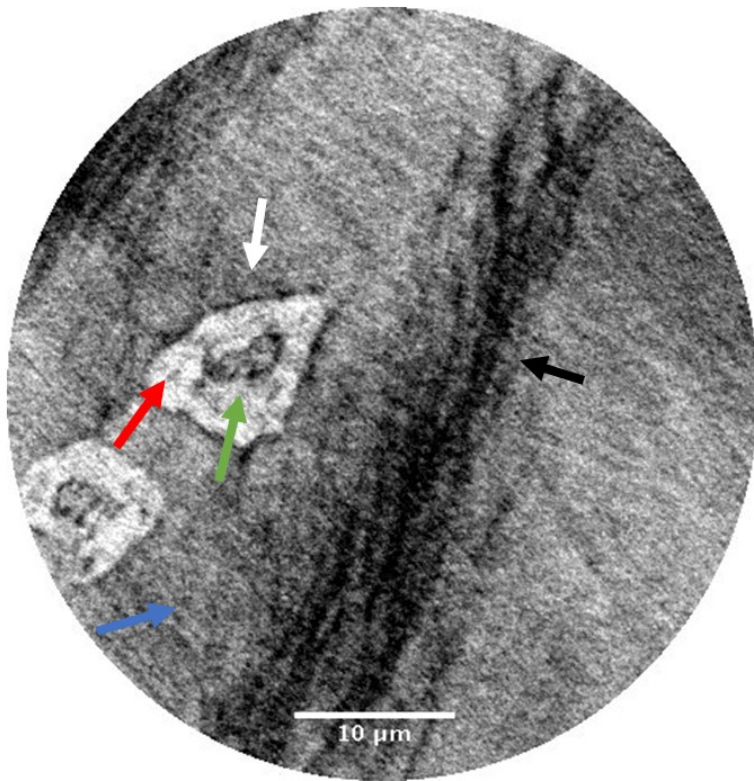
Close-up X-Ray image of OA cartilage: Chondrocytes (white arrow) with nucleus (green arrow) and shadow of cell organelles (red arrow) and fiber bundles of collagen with proteoglycans (black arrow) are visible. The blue arrow indicates the interterritorial matrix
